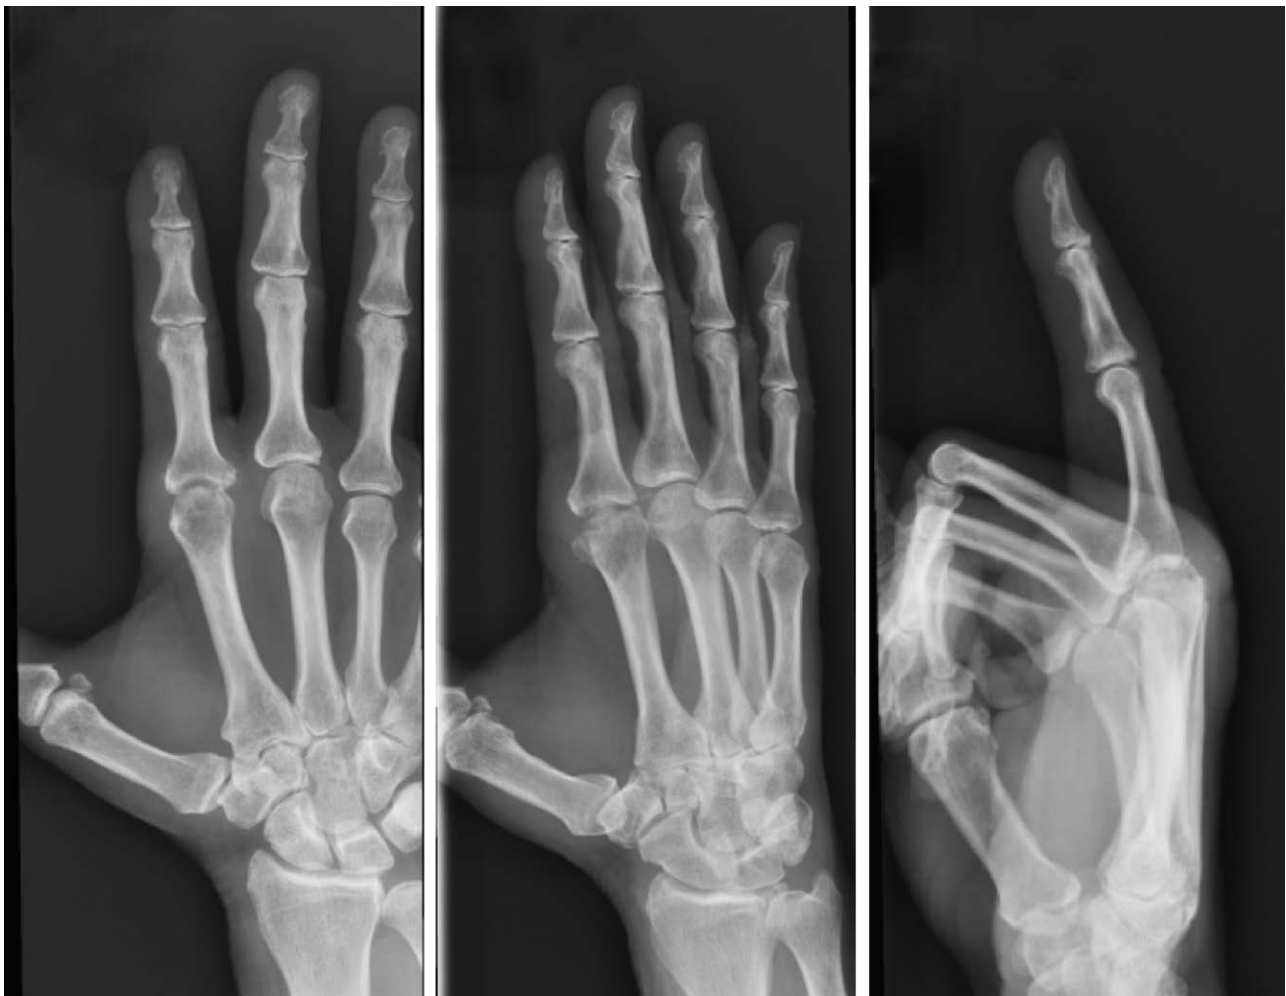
Patient 10, preoperative x-rays of nontraumatic osteoarthritis of the right index finger.
